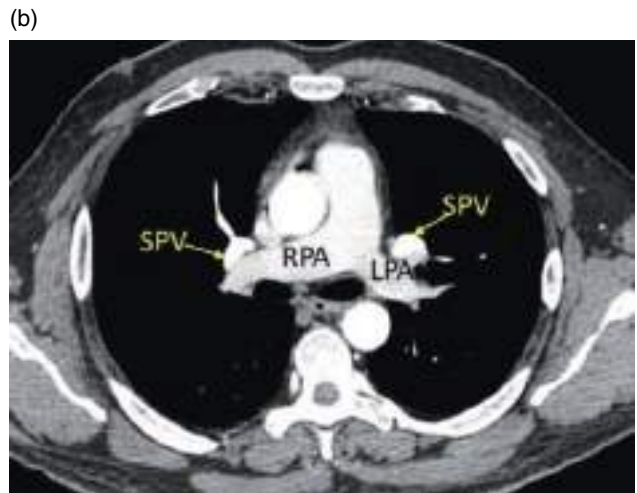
(a) Axial CT image (lung window). IB, intermediate bronchus; ST, superior trunk. (b) Axial CT image (mediastinal window). RPA, right pulmonary artery; LPA, left pulmonary artery; SPV, superior pulmonary vein.
